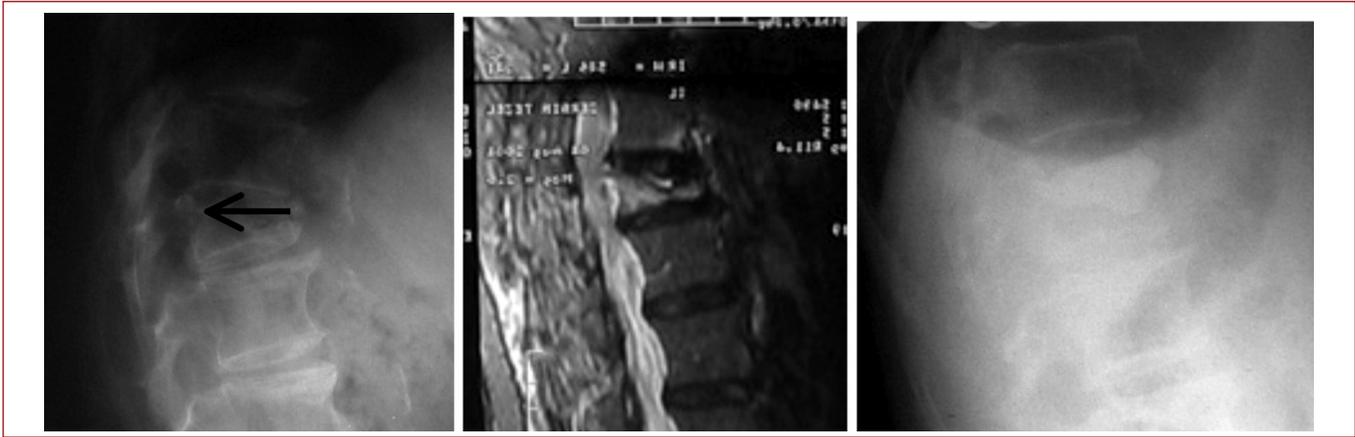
L1 X-ray showing a vacuum phenomenon in the vertebral body of a patient with Kümmel's Disease (Black arrow). The patient's STIR MRI image shows hyper-intense signals coming from the lesion at the same region. When the patient was laid in a prone position the local kyphosis disappeared, and vertebroplasty was applied to two pedicles in this position.
